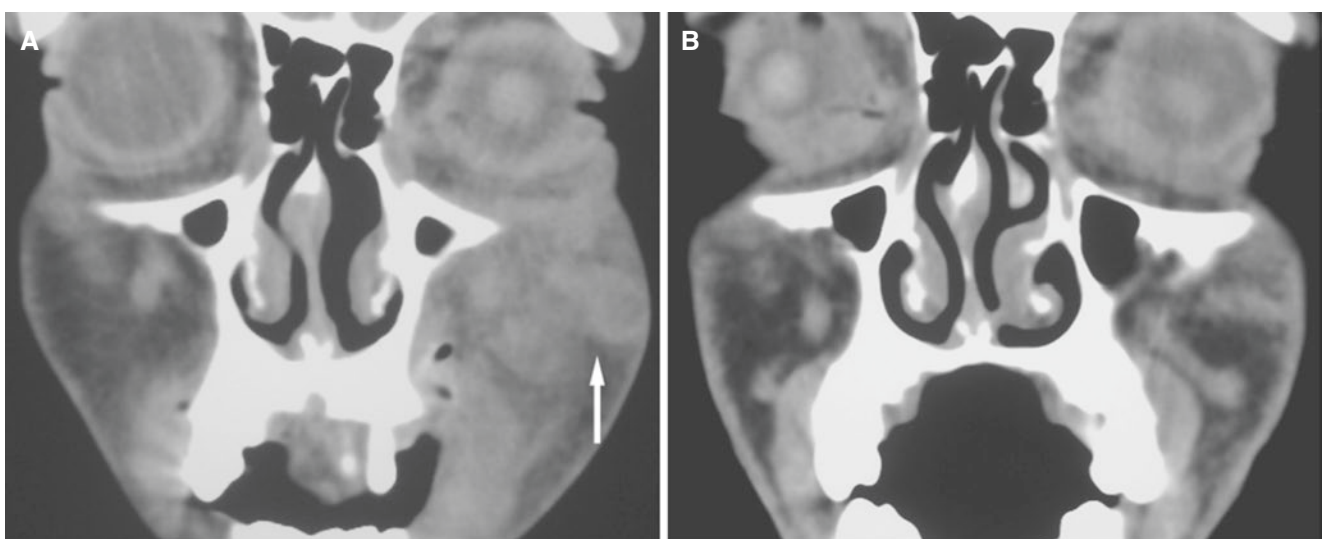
Abscess in cheek; 31-year-old female with dental infection with pain and swelling in the palate and cheek (history of multiple dental abscesses). (A) Coronal post-contrast CT image, soft-tissue window, shows soft-tissue swelling in the palate, small gas collections close to
